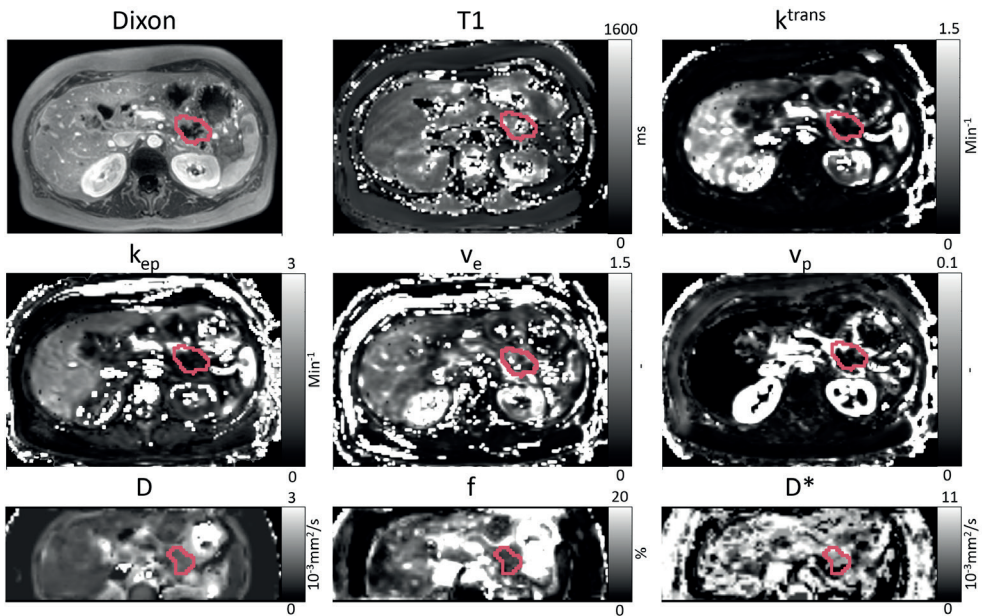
Example of an anatomical image (Dixon), T1 map, parameter maps of DCE MRI (k_{trans} , k_{ep} , v_e and v_p) and parameter maps of IVIM-DWI MRI (D, f and D^*) for one patient at baseline. The primary tumor is manually delineated in red. The delineation is performed separately for IVIM-DWI and DCE MRI scans.
